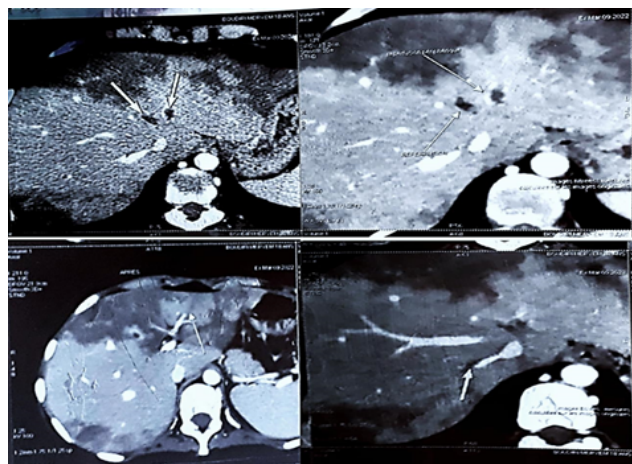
A: Abdominal CT angiography absence of opacification of the 2 supra-hepatic veins, associated with a congestive aspect of the hepatic parenchyma. B: CT angiography absence of liver dysmorphism.
